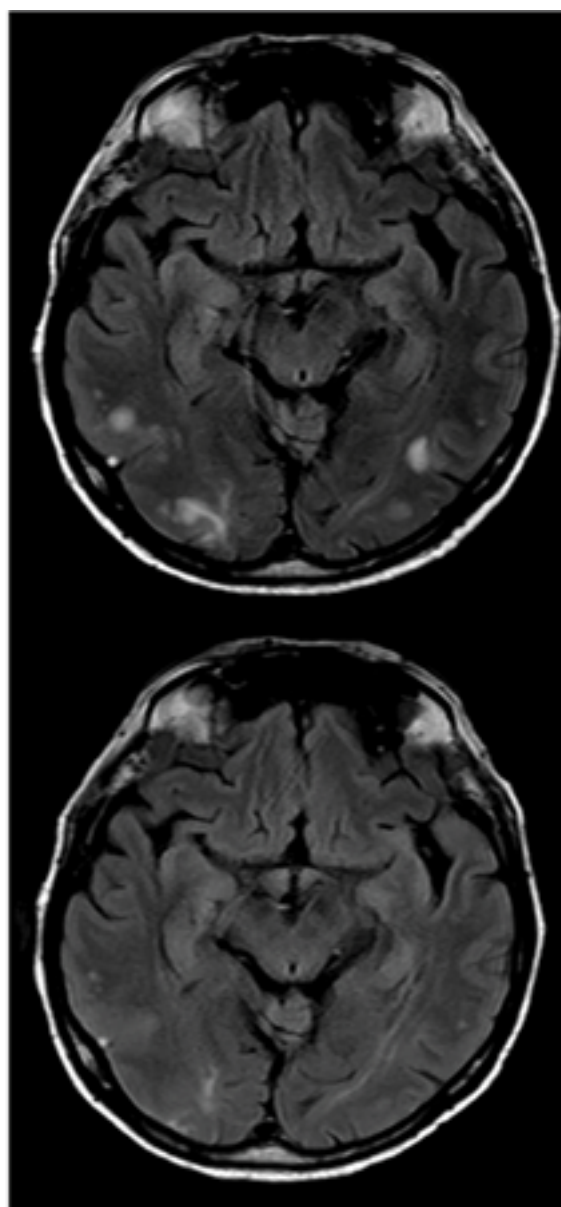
Follow up MRI at day 14 (fluid attenuated inversion recovery): dramatic reduction of vasogenic oedema with only persistence of a mild hypersignal of the right.
